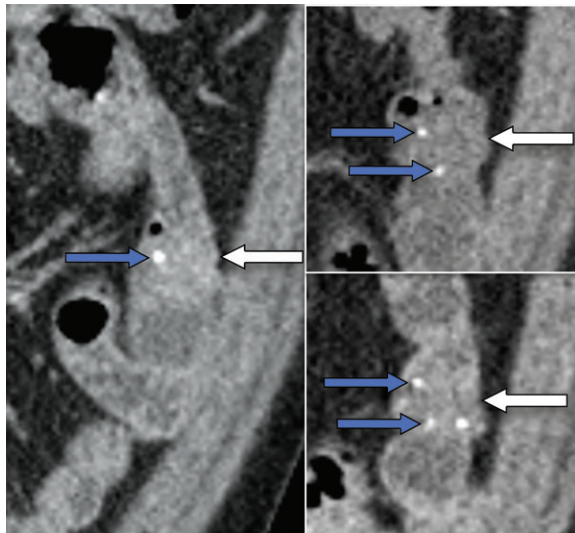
Small bowel hemangioma with calcified phleboliths in a 48-year-old man with iron deficiency anemia, a positive fecal occult blood test result, and a nodular erythematous lesion at capsule endoscopy. Coronal delayed phase (left image), arterial phase (top right image), and enteric phase (bottom right image) CTE images show a progressively enhancing small bowel mass (white arrow in all images), containing several calcified phleboliths (blue arrows in all images). On multiphasic CT images, phleboliths are best visualized in the earliest postcontrast phase, which in this case is the arterial phase. (Reprinted, with permission, from reference 13.)
